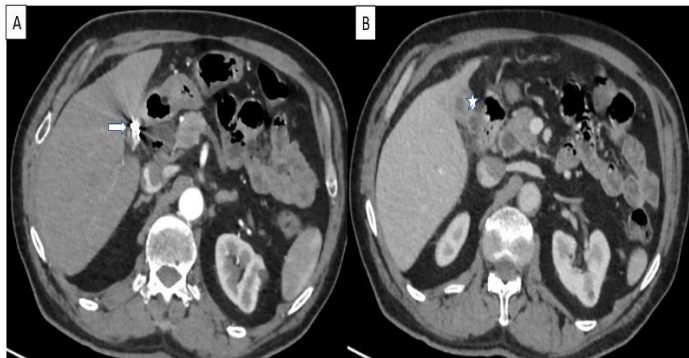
A,B After the six months of embolization, control upper abdomen CT revealed embolization material in the gallbladder fossa (arrow), post-operative changes in the gallbladder (star)
